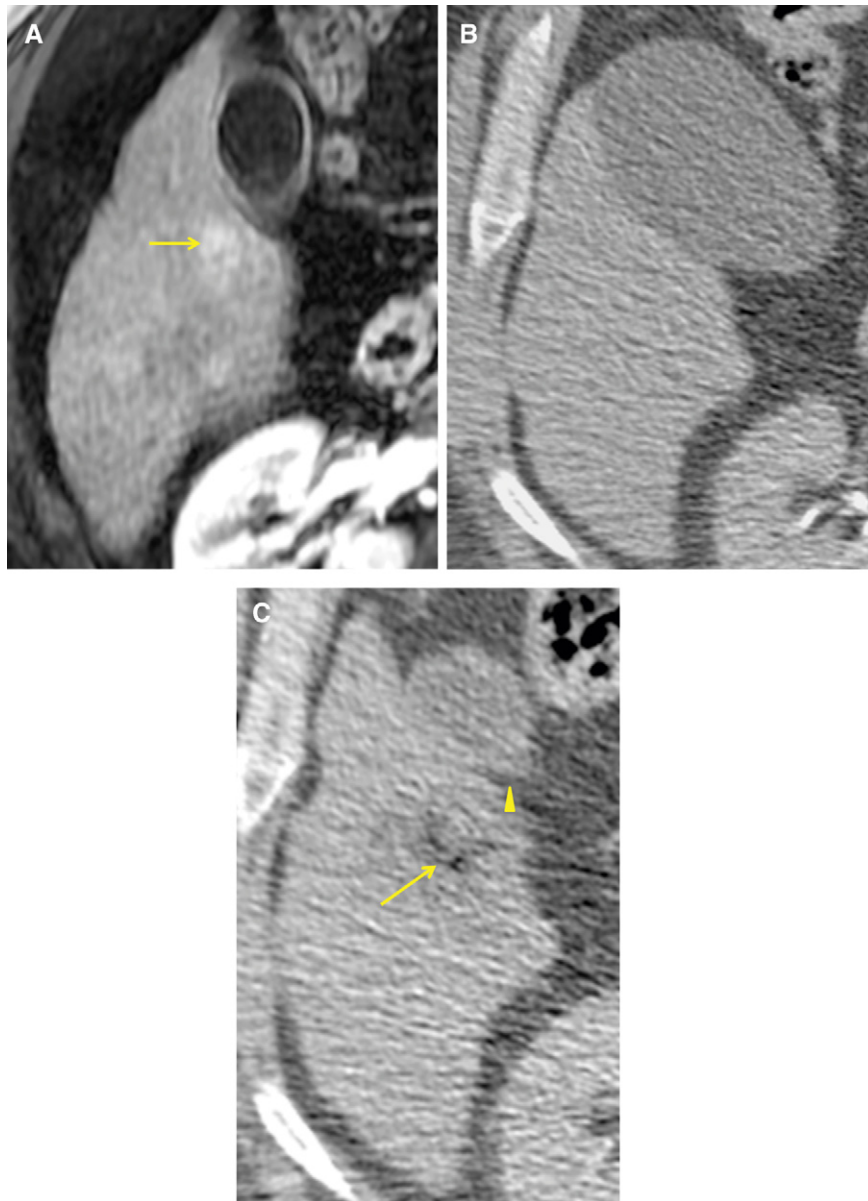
(A) Axial contrast-enhanced T1-weighted magnetic resonance image, demonstrating a hyperenhancing hepatocellular carcinoma in close proximity to a moderately distended gallbladder (arrow). (B) Axial unenhanced computed tomography (CT) image obtained immediately before ablation, demonstrating a distended gallbladder closely apposed to the liver capsule overlying the anticipated ablation zone. (C) Axial unenhanced CT image obtained immediately after radiofrequency ablation, showing a region of hypodensity with gas bubbles (arrow) in the hepatic ablation zone extending to the liver capsule; the decompressed gallbladder (arrowhead) is retracted from the ablation zone.
